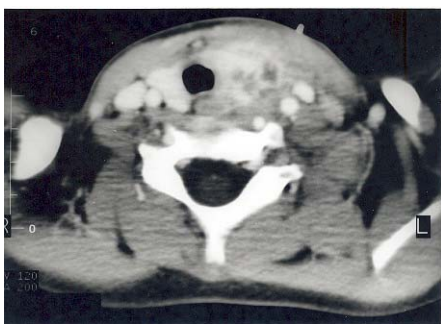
Contrast enhanced axial computed tomographic image shows abscesses involving the left thyroid lobe and adjacent perithyroid soft tissue. There is deviation of the trachea to the right.
